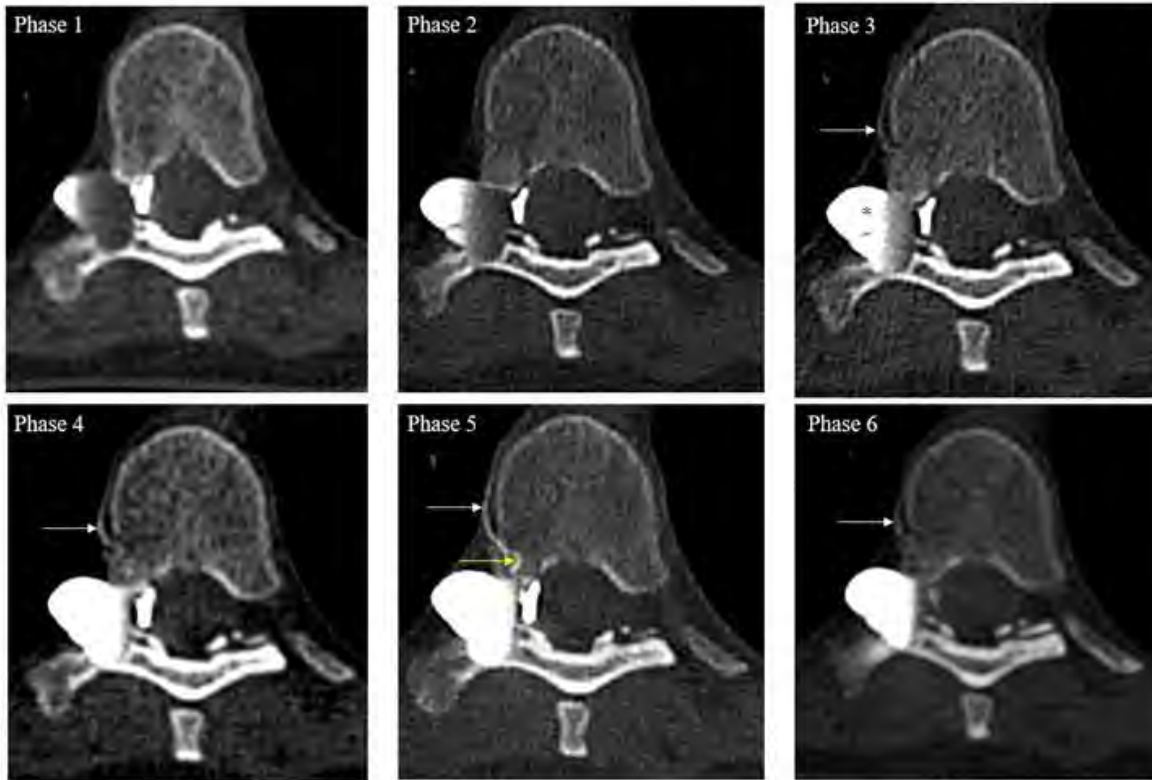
DLDTM with 6 acquisitions (phases 1-6) performed in the right lateral decubitus position for evaluation of patient in 70s presenting with daily headaches and MRI findings highly suggestive of SIH. Paraspinal venous enhancement consistent with CVF (arrows) associated with a large diverticulum (asterisk, largest diameter = 16 mm) was identified beginning at phase 3, most conspicuous at phase 5, and visualized until the last phase (phase 6). The CVF was not apparent on phases 1 and 2. (DLDTM: Dynamic Lateral decubitus CT myelogram, SIH: Spontaneous Intracranial Hypotension, CVF: CSF-Venous Fistula)
